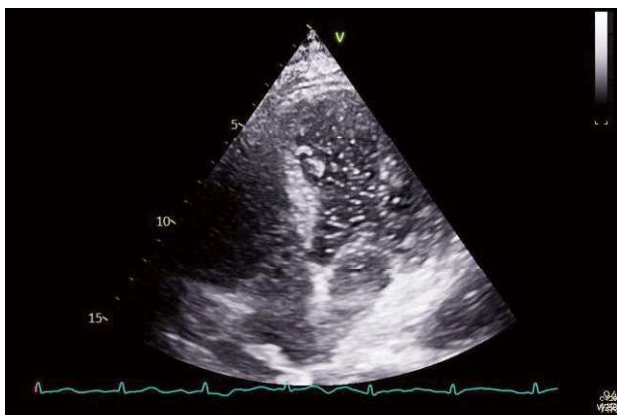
Air bubbles in the left ventricle, which indicated a positive finding in the contrast echocardiogram.
